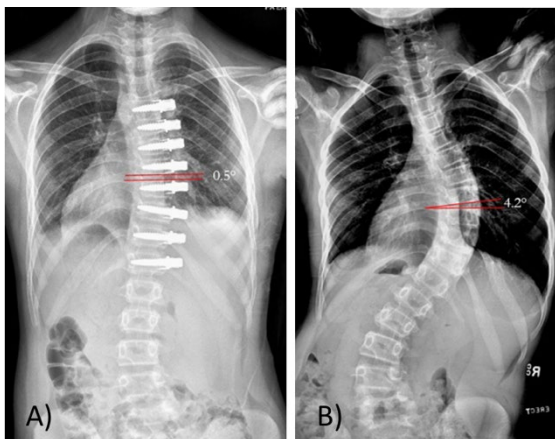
Radiographs displaying the wedge angle of the T8/9 IVD at A) pre-operative, B) 1-week postoperative.
